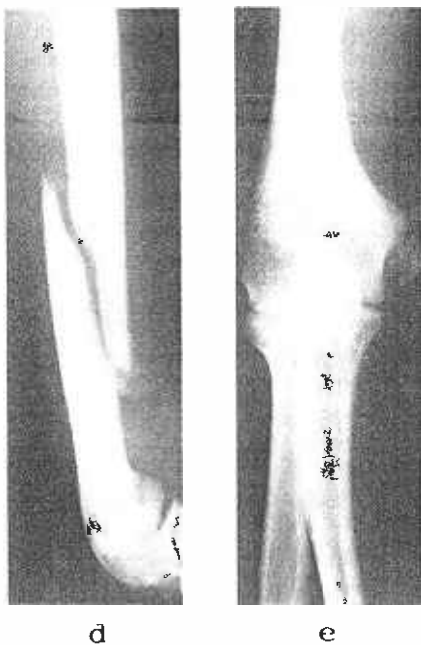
Fig f. Case 5 – follow-up X-rays showed no mechanical obstruction or significant mal-alignment.
